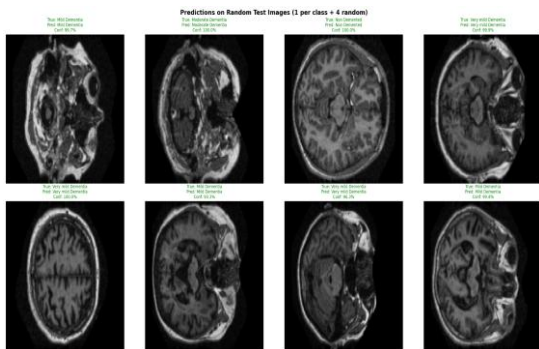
Sample MRI Brain Images
